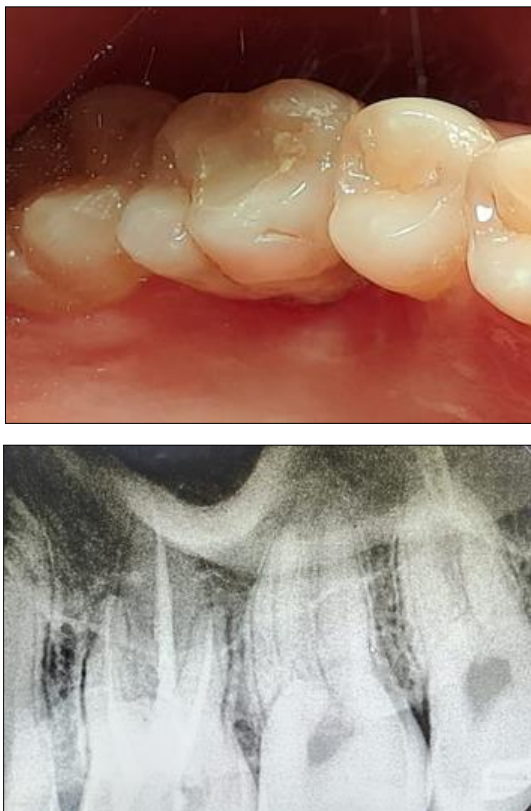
Postoperative (a) Clinical picture, (b) Radiographic picture after 11 month follow up.
